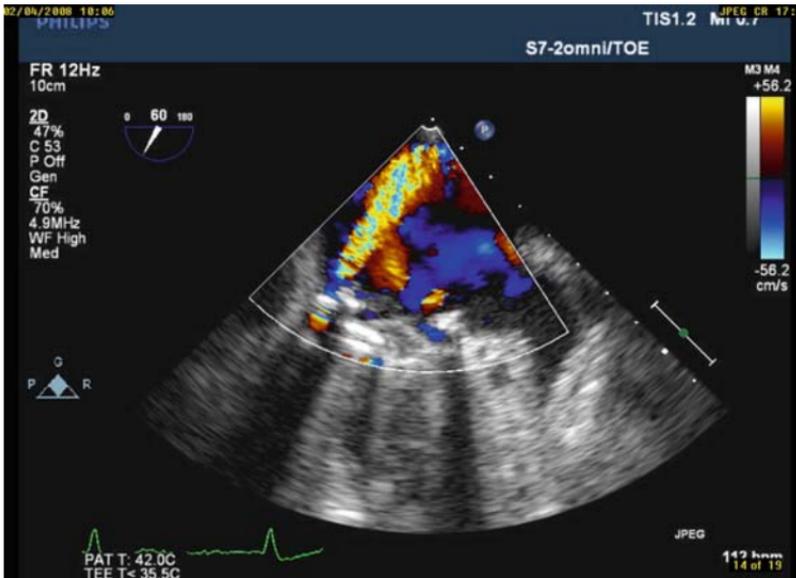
Transesophageal echocardiography (TEE) findings in a patient with a bileaflet mechanical valve in mitral position, admitted with cardiac failure and hemolytic anemia. A high velocity, turbulent regurgitant jet is seen, originating at the suture line level consistent with significant paravalvular regurgitation.
